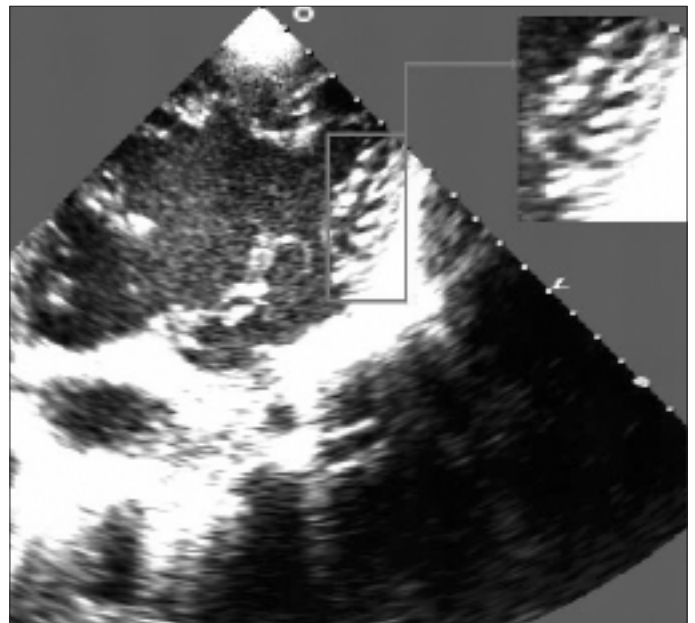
Two-dimensional echocardiography view of deep intertrabecular recesses
